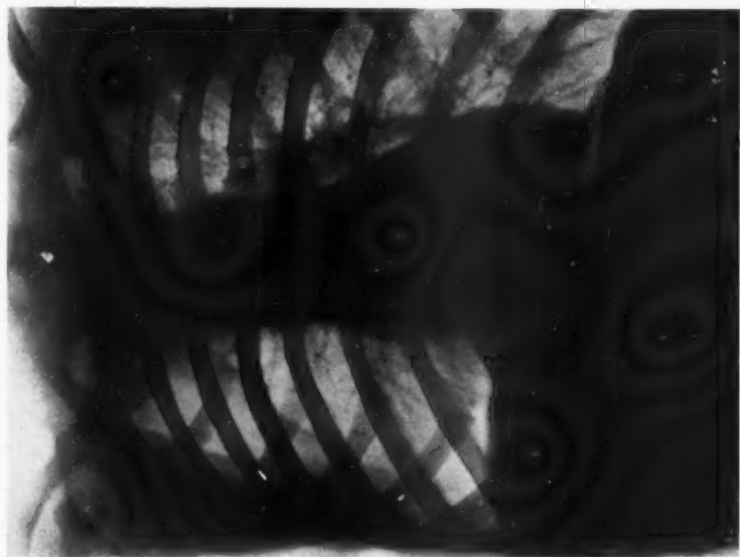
An ordinary radiograph.
